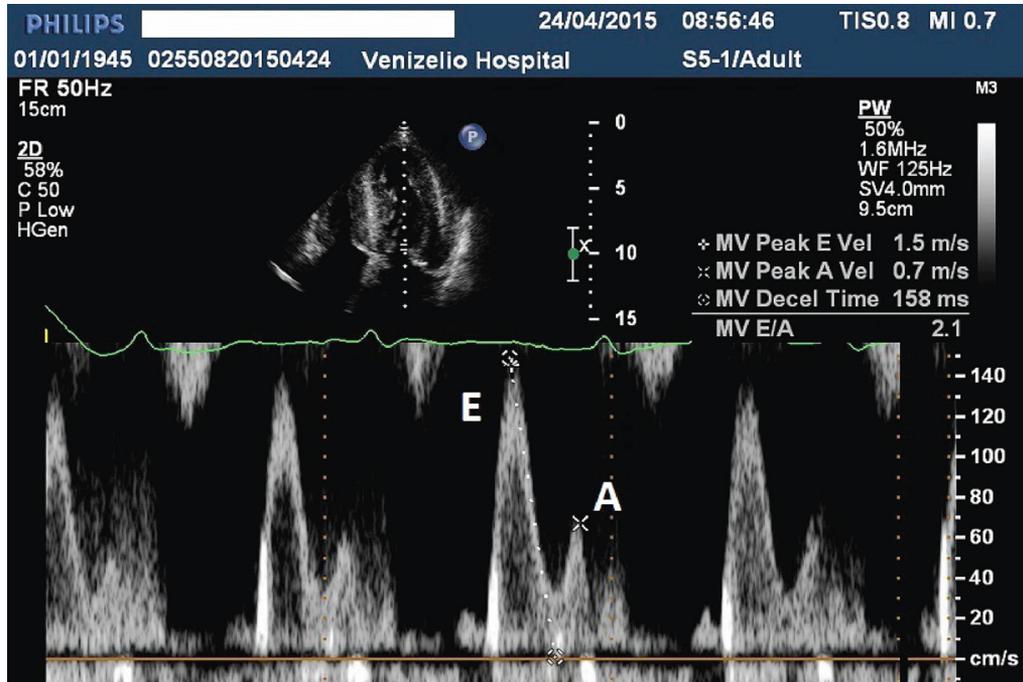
Doppler-derived LV diastolic filling showed a trans-mitral early filling wave declaration time of 158 ms and an elevated E/A ratio 2:1.
